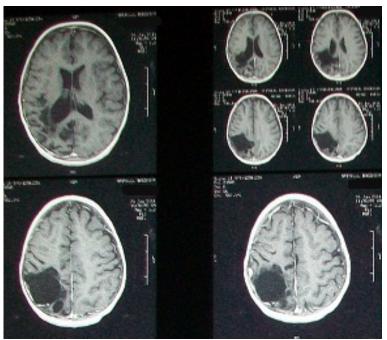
Four months postoperative MRI
